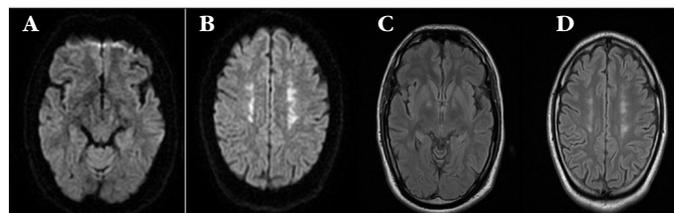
A 31-year-old male, carbon monoxide intoxication, clinical improvement after hyperbaric oxygen therapy, significant regression of the lesions in diffusion-weighted images (A, B) and FLAIR (C, D) magnetic resonance imaging performed at the 3rd week
